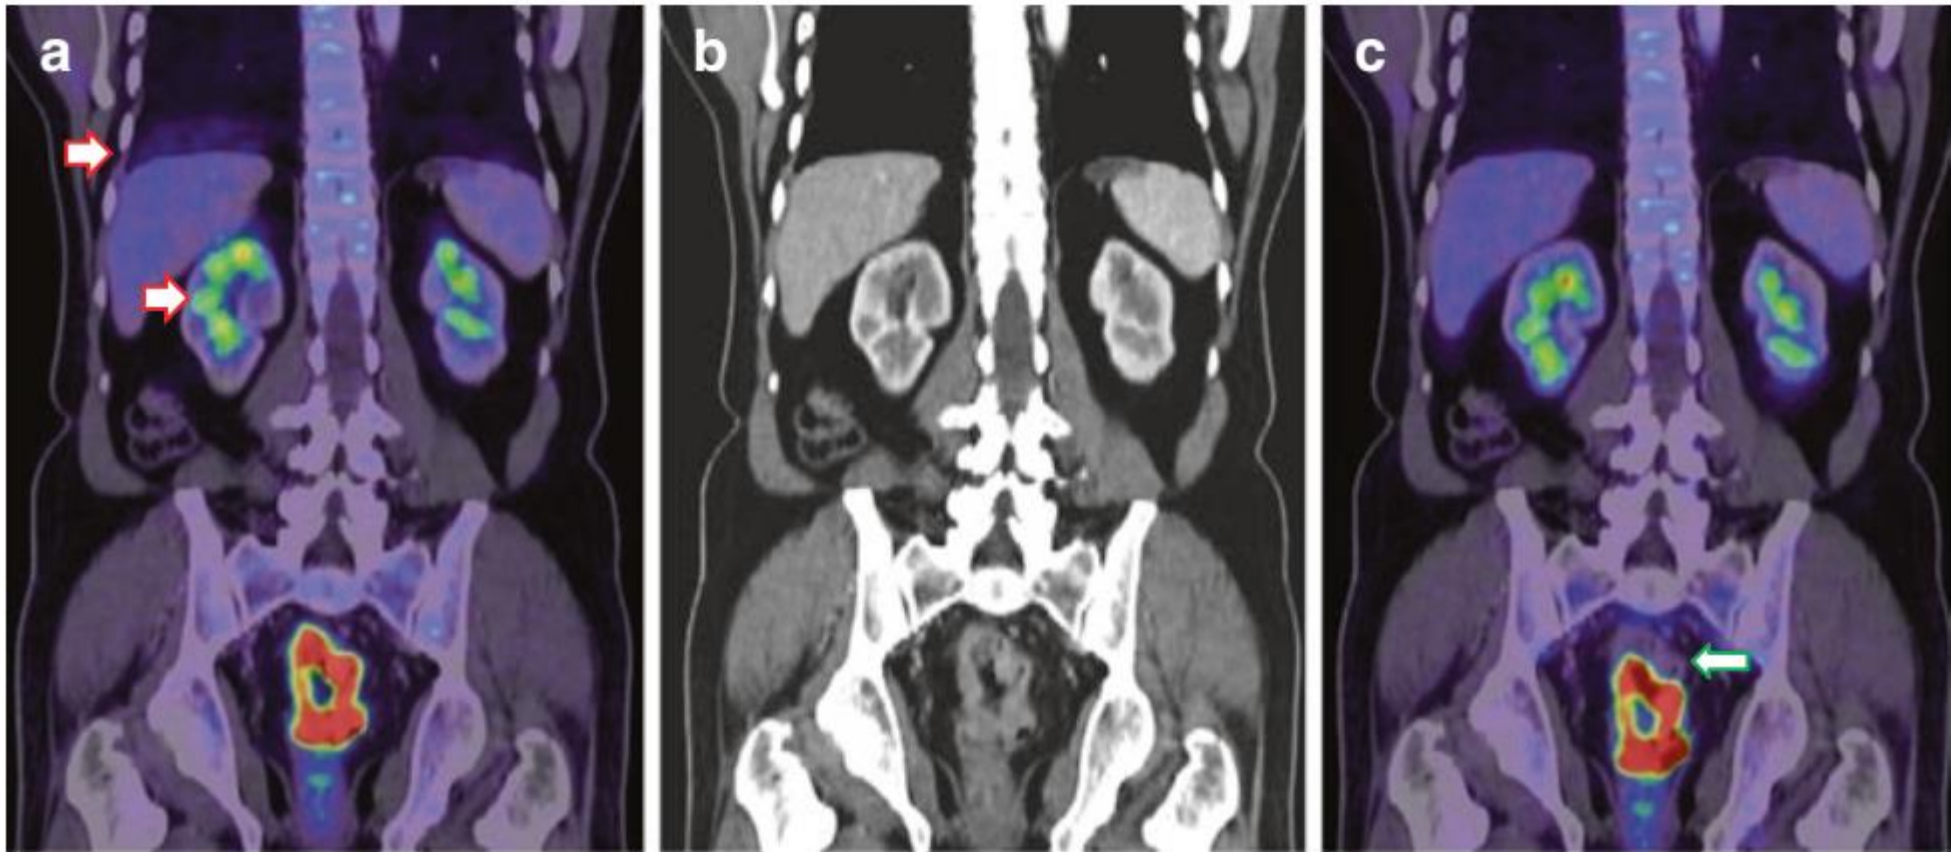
Misregistration of liver and renal FDG uptake (a - coronal fused PET/CT, b – coronal contrast enhanced CT) due to respiratory movement (*red arrows*). (c) Images after manual correction for misregistration of liver and renal activity, but it induces misregistration at the site of pathological FDG uptake in the lesion in the rectum (*green arrow*). Care should be taken while interpreting images with misregistration
